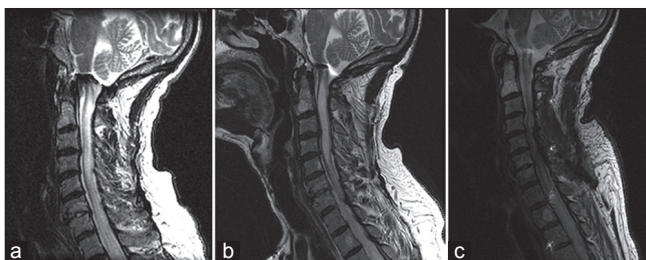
Sagittal T2-magnetic resonance imaging showing syringomyelia at presentation to UI neurosurgery. (a) One year after presentation. (b) Five months postoperatively. (c) The syrinx is decreased in size after syrinx-subarachnoid shunt
